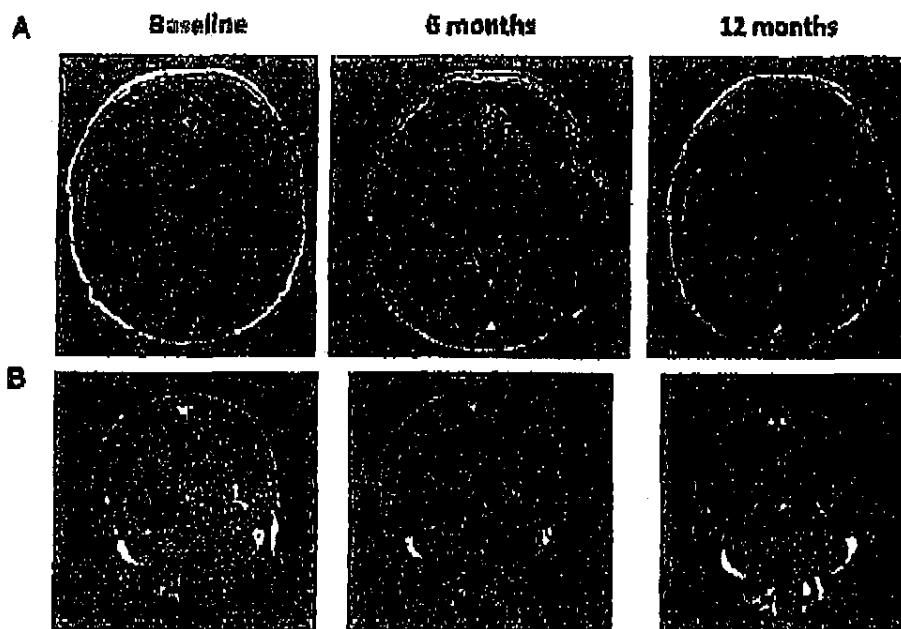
Exemplary T1 weighted magnetic resonance imaging (MRI) images with gadolinium from two Tumour Treatment Fields (TTF) patients with partial response to therapy. (A) A 48 years old male with prior grade II astrocytoma which transformed to glioblastoma (based on tissue biopsy). The subject progressed 7 months after receiving chemoradiotherapy, and subsequently responded to TTF therapy (partial response at 12 months) and remained stable for an additional 36+ months on TTF. (B) A 55 years old male with primary glioblastoma who recurred for the third time after receiving chemoradiotherapy, adjuvant temozolomide (2 cycles), bevacizumab with irinotecan (3 months) and etoposide with sorafenib (one cycle). The subject had a partial response to TTF therapy after 4 months of treatment and remained stable for an additional 8 months while on TTF.
